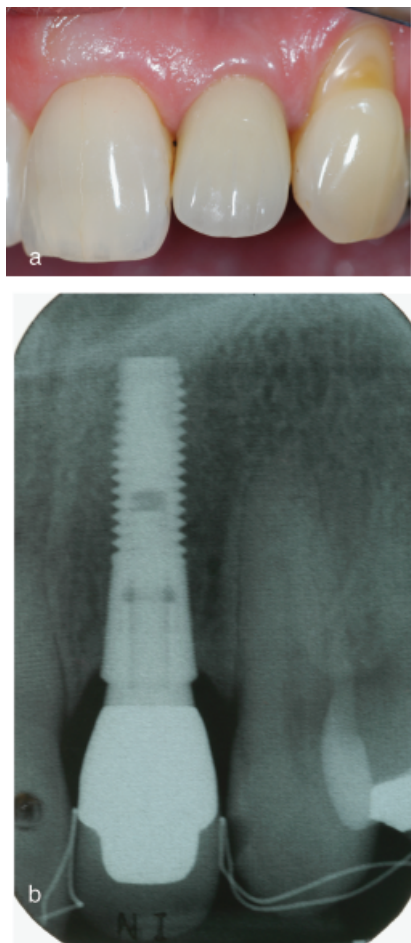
(a) Clinical photograph of a single-tooth implant restoration replacing a maxillary left lateral incisor with good tissue form and papillae scored as Jemt 2 on mesial and distal aspects. (b) Radiograph of the clinical case shown in Fig. 3a.
